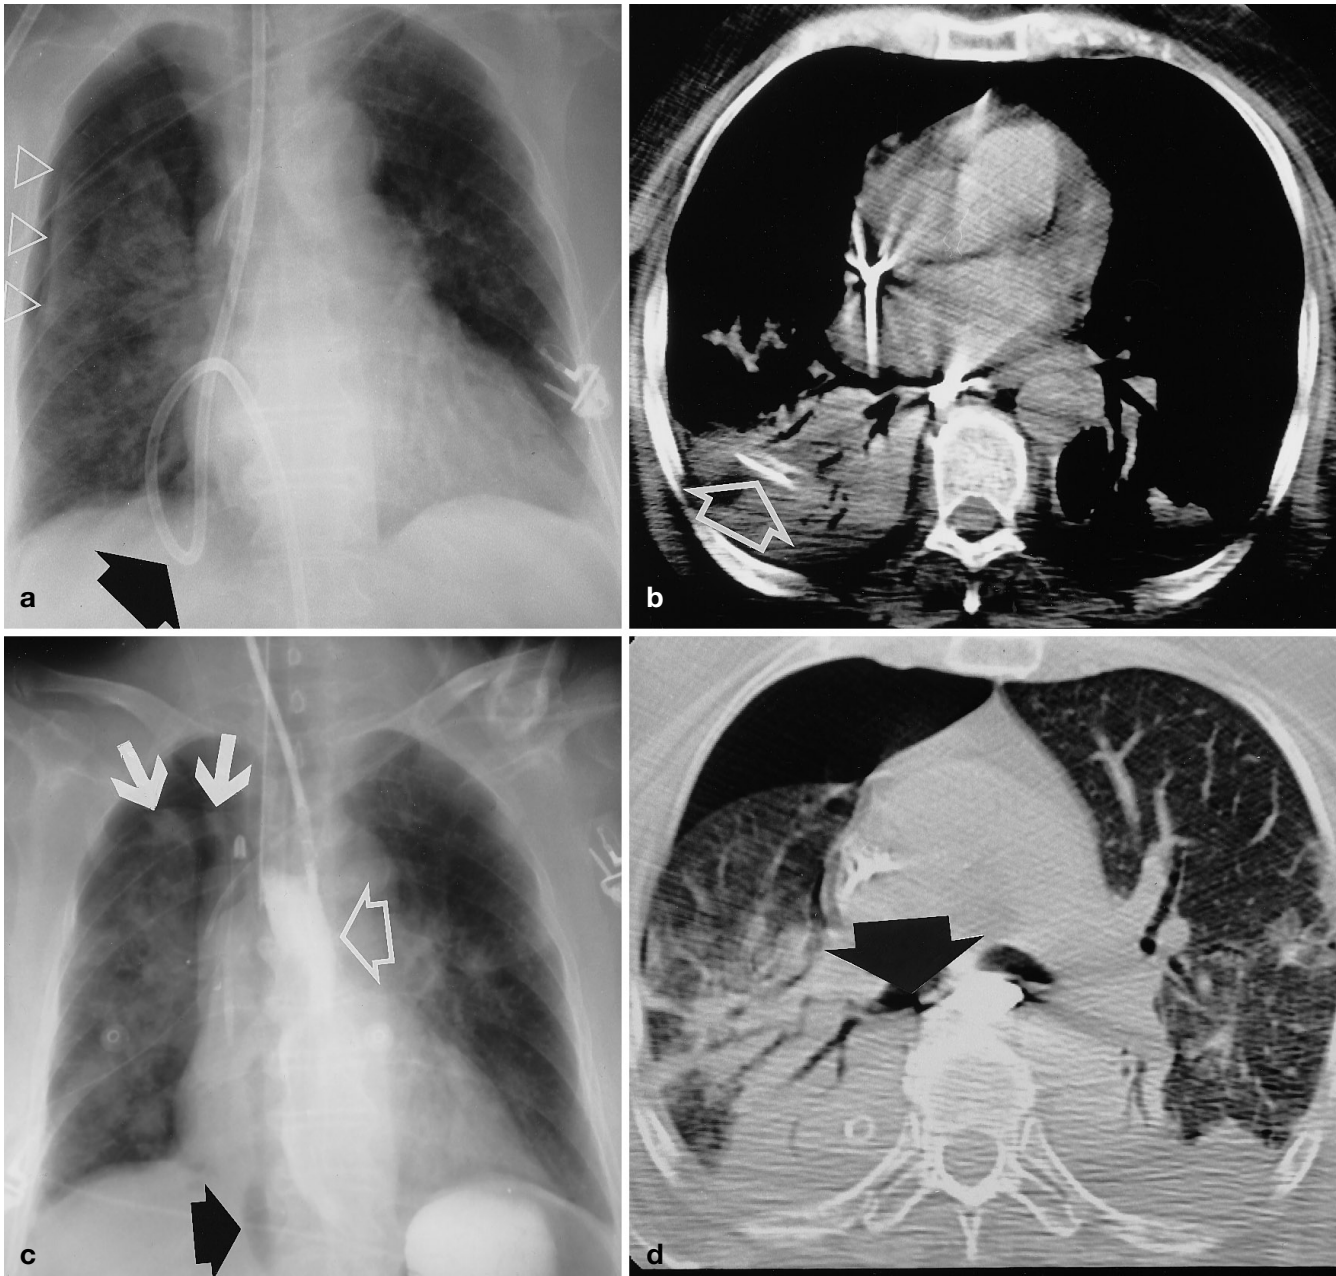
Supine chest radiographs and CT scans of a 71-year-old intensive care patient. A Postprocedural radiograph shows the nasogastric tube in the lung parenchyma and that the tube has entered via the tracheobronchial tree. The tube is curled (black arrowhead). The presence of a pneumothorax on the right side (white open arrowheads) suggests that the tube perforated the pleura. B Follow-up supine radiograph after intubation, pleural drainage, and retrieval of the nasogastric tube shows persistent lateral and paramediastinal pneumothorax (white arrows) and also
